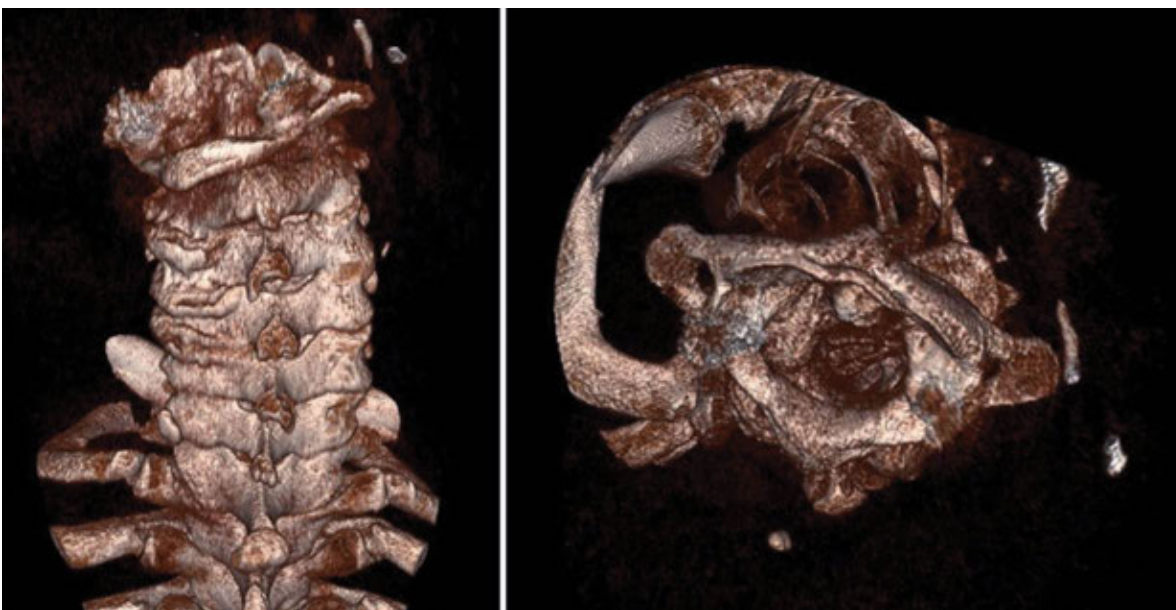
3D CT reconstruction demonstrating Fielding Type I atlantoaxial rotatory fixation. The odontoid acts as a pivot point, with the left C1 facet subluxating anteriorly and the right C1 facet subluxating posteriorly. There is no anterior displacement.
